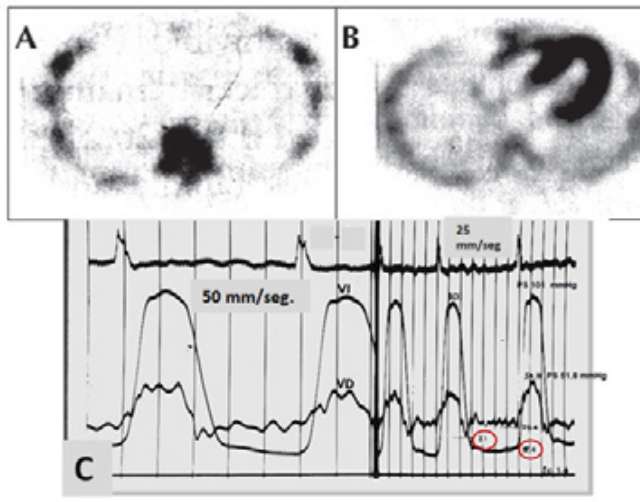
Cardiac scintigram with 99MTC- DPD. A) Negative cardiac scintigram (absence of radioisotope uptake). B) Cardiac scintigram that captures the radioisotope and demonstrates the diagnosis of cardiac amyloidosis. C) In cases of amyloidosis, the ventricular filling pattern rarely shows elevated filling pressures with a slow relaxation pattern.
